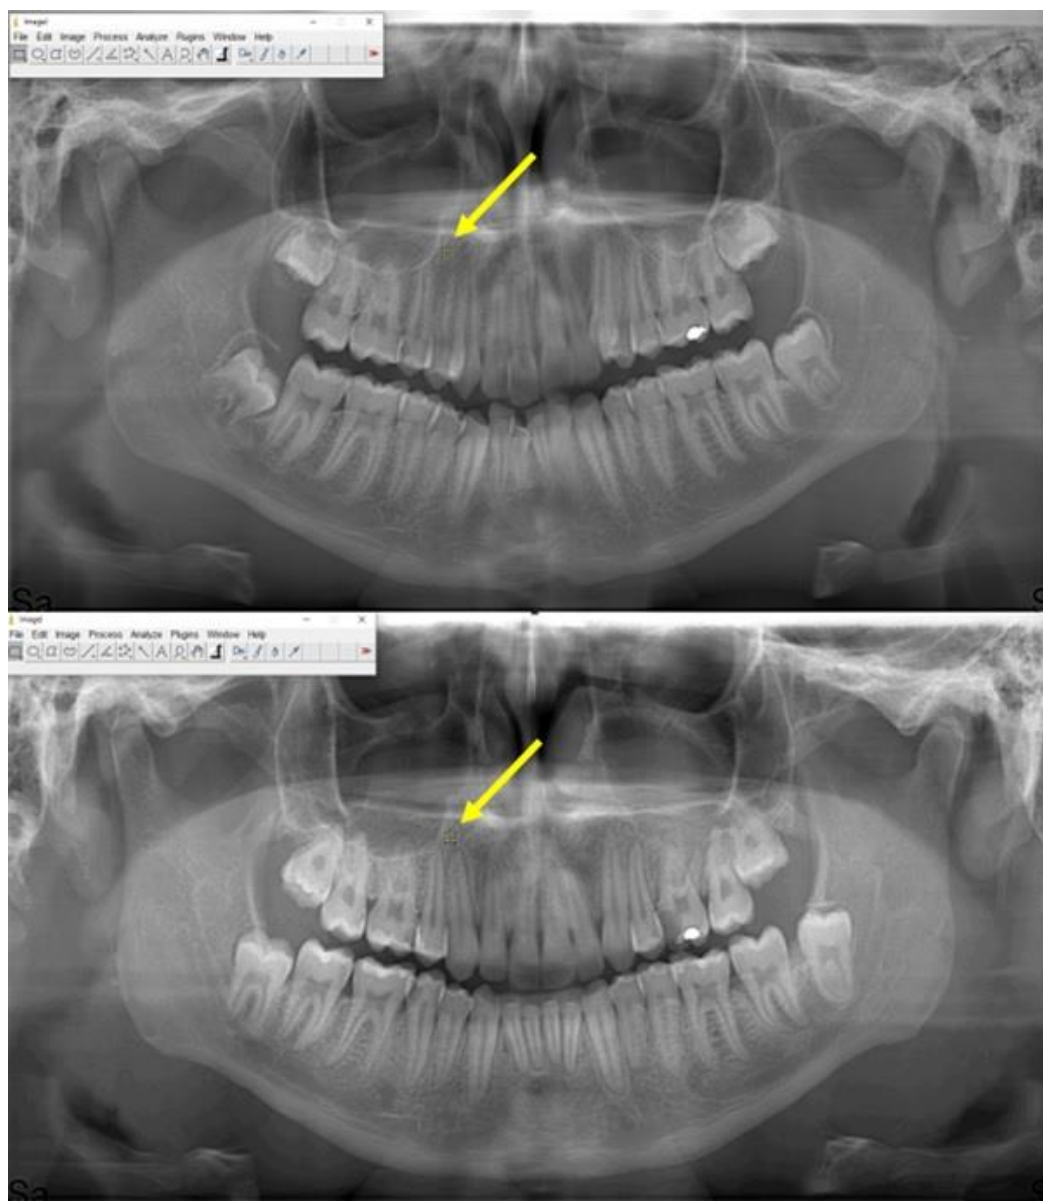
Determining a 20 x 20 pixel region of interest in panoramic radiography before and after extraction
